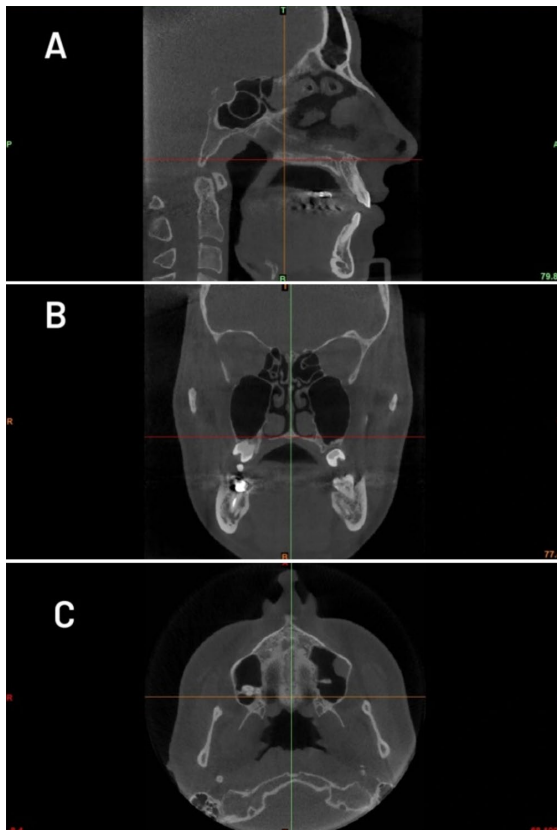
Standard 3D reconstruction of CBCT images. The center of the image was at the hard palate on the axial view; (A) sagittal view; (B) coronal view; (C) axial view
